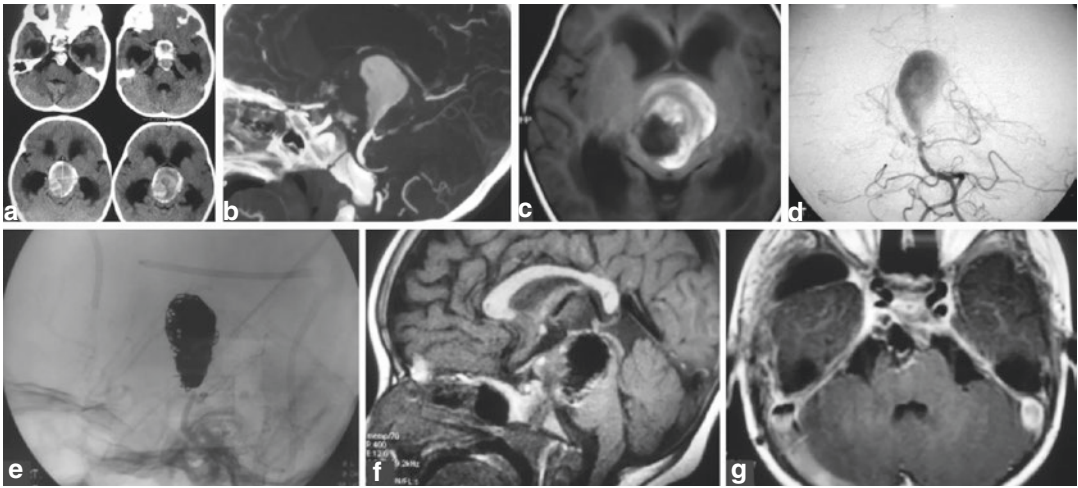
(a–d) Plain CT, CTA, MRI, and DSA showing a 4.5 cm giant, calcified, partially thrombosed basilar top aneurysm. (e) Post-EVT DSA demonstrating successful complete occlusion of the aneurysm by coils. (f, g)
